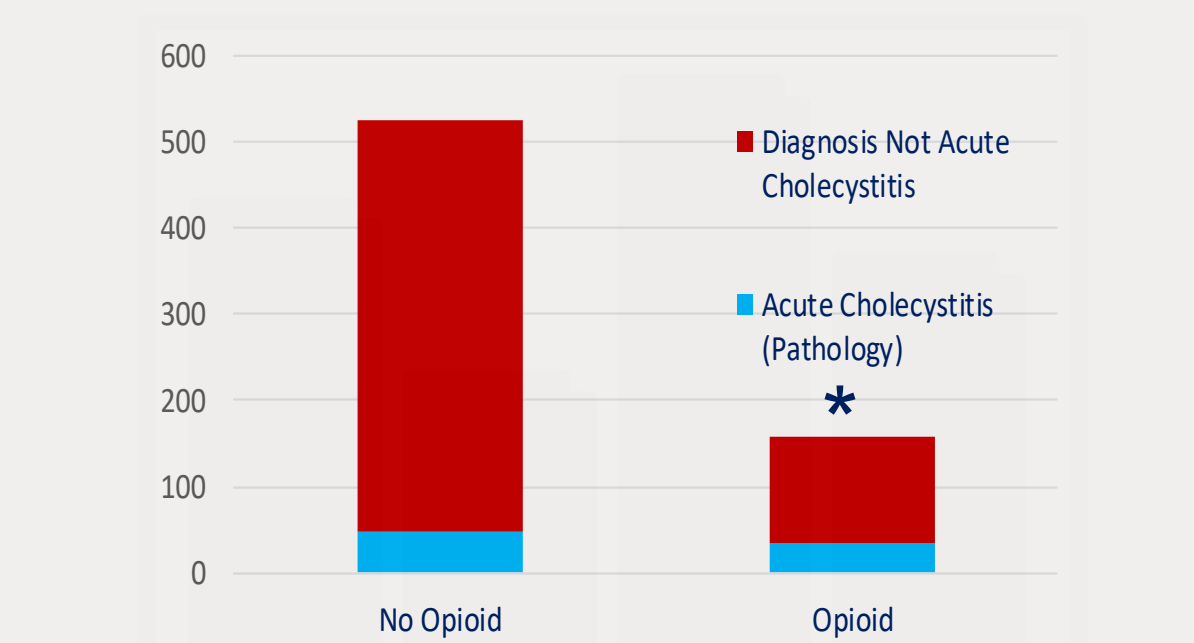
Premedication with opioids prior to ultrasound was significantly associated with a pathologic diagnosis of acute cholecystitis versus other diagnoses (P<.0001).
